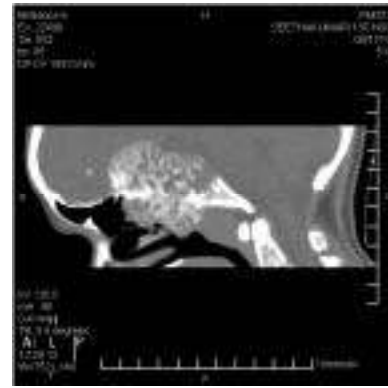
Sagittal reconstruction of a CT image showing the bony trabeculae within the lesion (honeycomb pattern); it extends from the anterior cranial fossa (ACF) base till the clivus posteriorly
